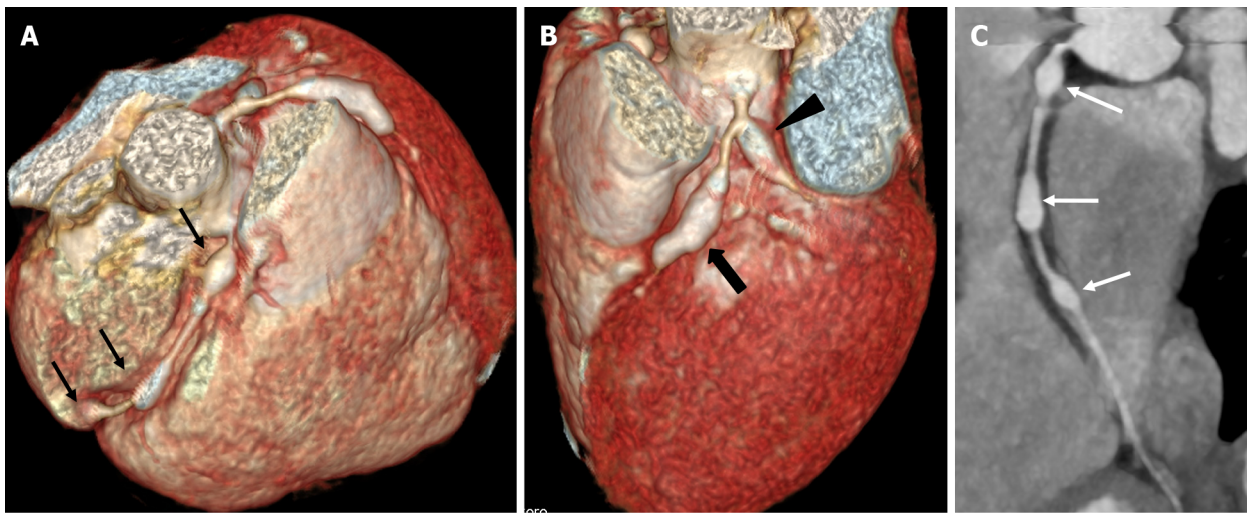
Computed tomography coronary angiography images showing its strength to evaluate coronary artery abnormalities in left circumflex artery. A: 3 years male child at presentation shows fusiform aneurysm at bifurcation of left main coronary artery [left main coronary artery (LMCA)- thick arrows in A and B] with extension into ostio-proximal segment of left anterior descending (LAD). Note a skip fusiform aneurysm in proximal LAD (thin arrow in b). C: Proximal and mid segments of left circumflex (LCX) are dilated (arrow heads in C). Echo demonstrated LMCA and LAD aneurysms however cannot evaluate LCX due to its orientation and course.
